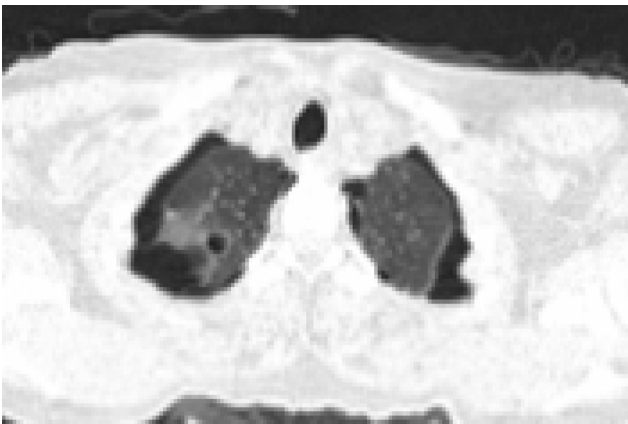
HRCT chest showing bilateral residual pneumothorax.
